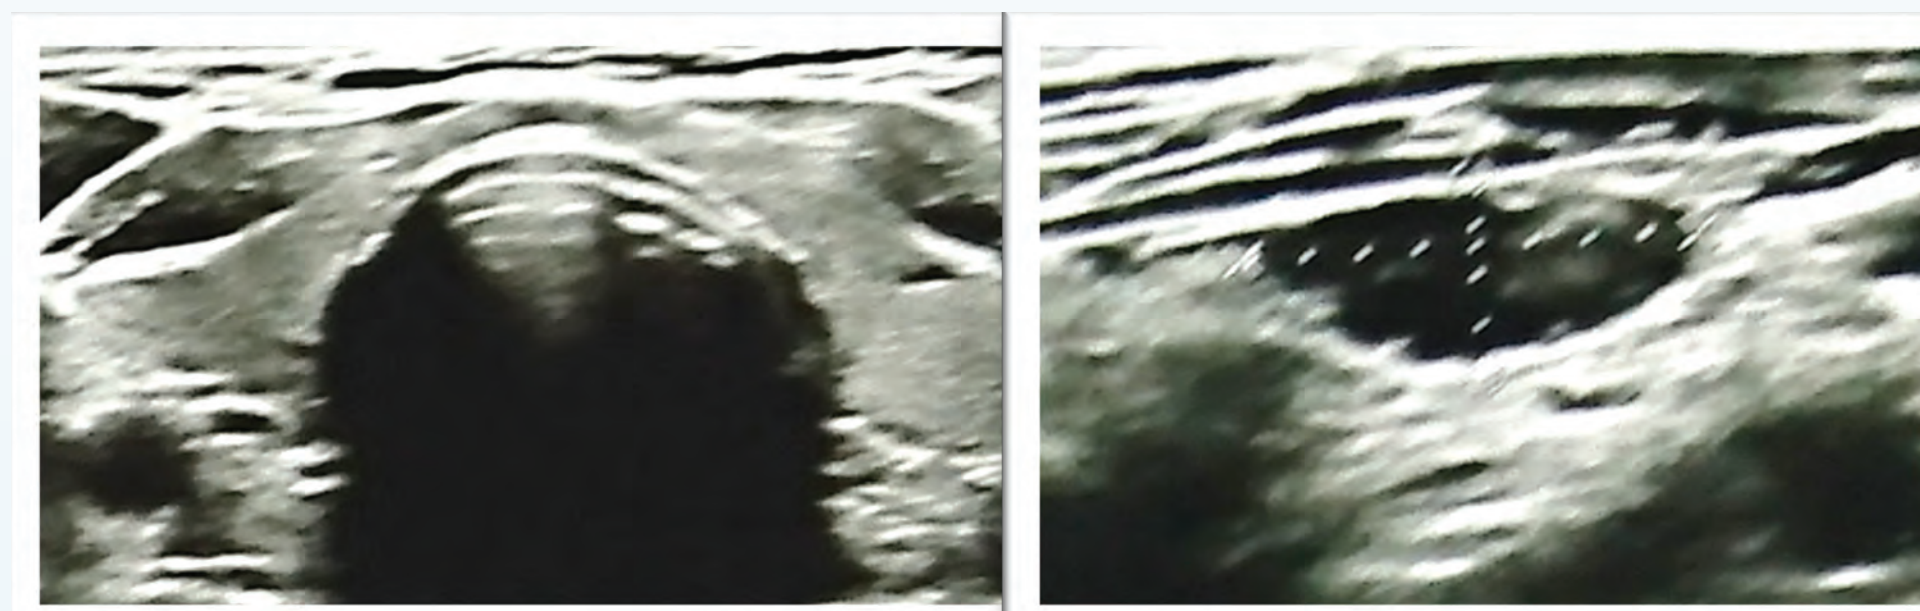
Suspected enlarged left lower parathyroid gland on neck ultrasound.
